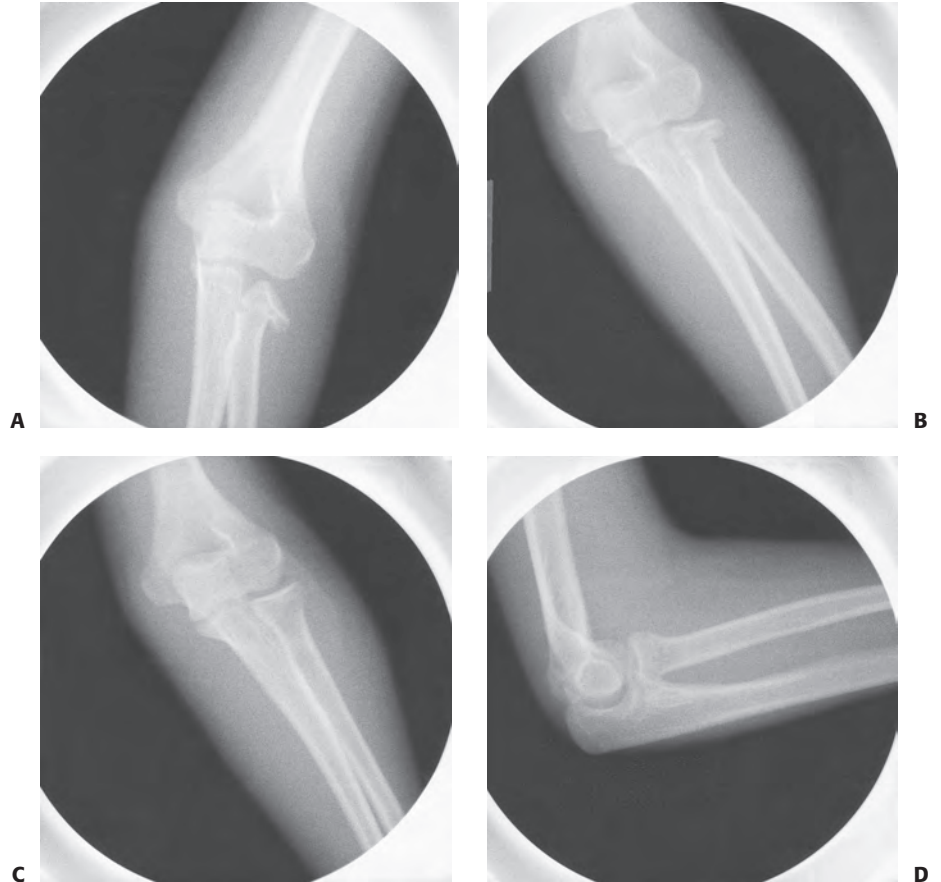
A: Radial neck fracture angulated 45 degrees in a 14-year-old female. B: Radiograph after closed reduction using thumb pressure on the radial head. C: Final reduction after manipulation of the distal fragment with an elevator using the Wallace technique. D: Lateral view of the elbow after reduction.
